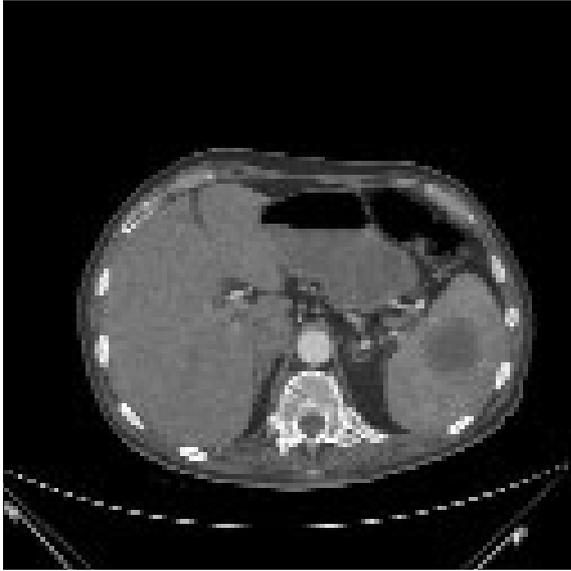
CT scan of the abdomen showing a 5 x 5.6 cm splenic mass
